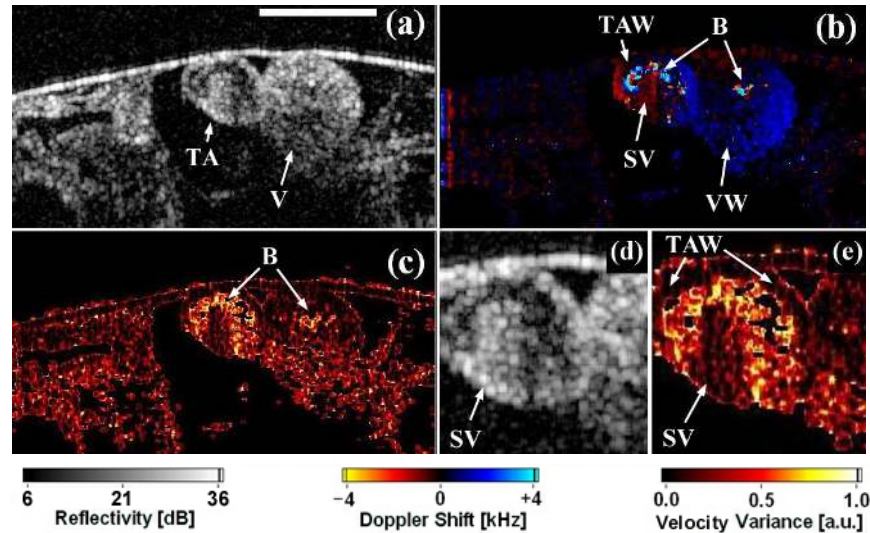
DOCT video of the stage 46 *Xenopus* tadpole heart, acquired at 8 fps [305 kB]. (a) Structural video showing the ventricle (V) and truncus arteriosus (TA). The atria are also visible in the video (not shown in this static frame). Scale bar = $500 \mu\text{m}$. (b) Color-Doppler video showing the blood flow (B) within the ventricle and the truncus arteriosus. Notice the homogeneous distribution of Doppler shift in the ventricle wall (VW) and the truncus arteriosus wall (TAW). The partial division at the center of truncus arteriosus is probably the spiral valve (SA), also showing homogeneous Doppler shift distribution, distinct from the blood flow. A small blood vessel can also be seen in the video (not shown in this static frame). (c) Velocity variance video showing the blood flow (B). The blood flow, spiral valve, and the truncus arteriosus wall are better visualized in the $2 \times$ zoom videos, shown in structural mode (d), and velocity variance mode (e). Acquired at 450×508 pixels per frame before re-sampling for video compression.
